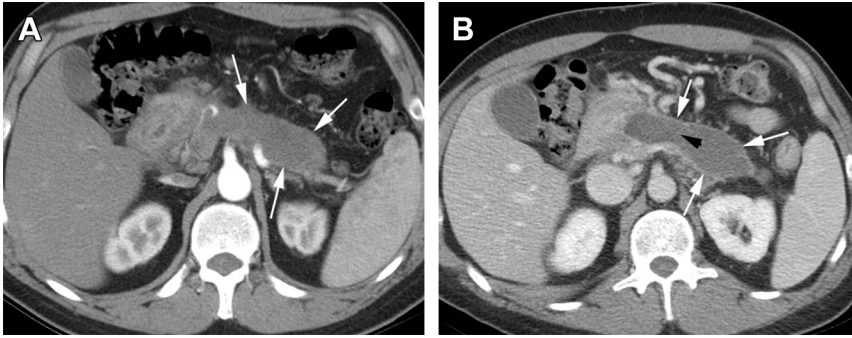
Acute necrotizing pancreatitis: pancreas parenchyma alone. (A) CT image in the axial plane of a 38-year-old woman taken 7 days after onset shows an area of nonenhancement in the tail and body of the pancreas (arrows). The ANC is slightly heterogeneous. (B) Axial CT image of the same patient as Fig. 6A, 5 weeks later. The ANC has developed into a WON with an enhancing wall (white arrows) and septation (black arrowhead). It remains an area of heterogeneous attenuation.
